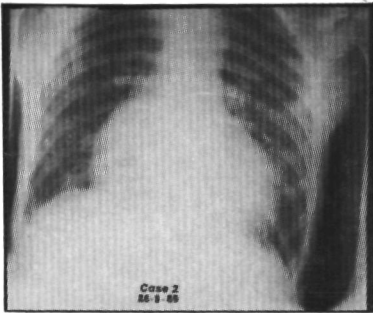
(Case 2). Chest roentgenogram taken on admission to hospital (left), and before discharge seven days later (right).
